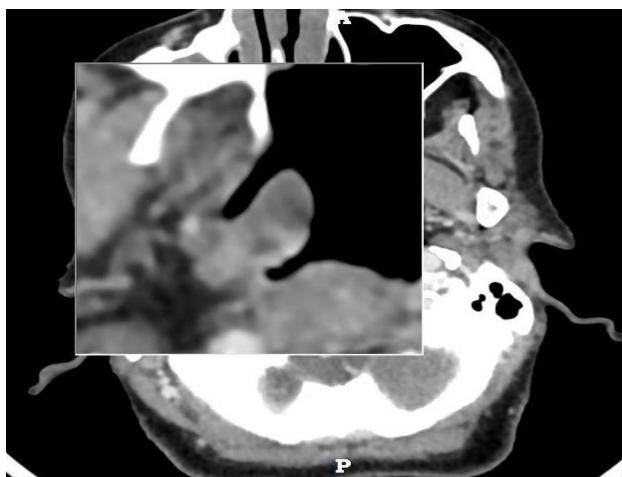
A normal right side torus tubarius; the radio-dense nature of torus tubarius in CT images than surrounding soft tissue due to its calcium content.
